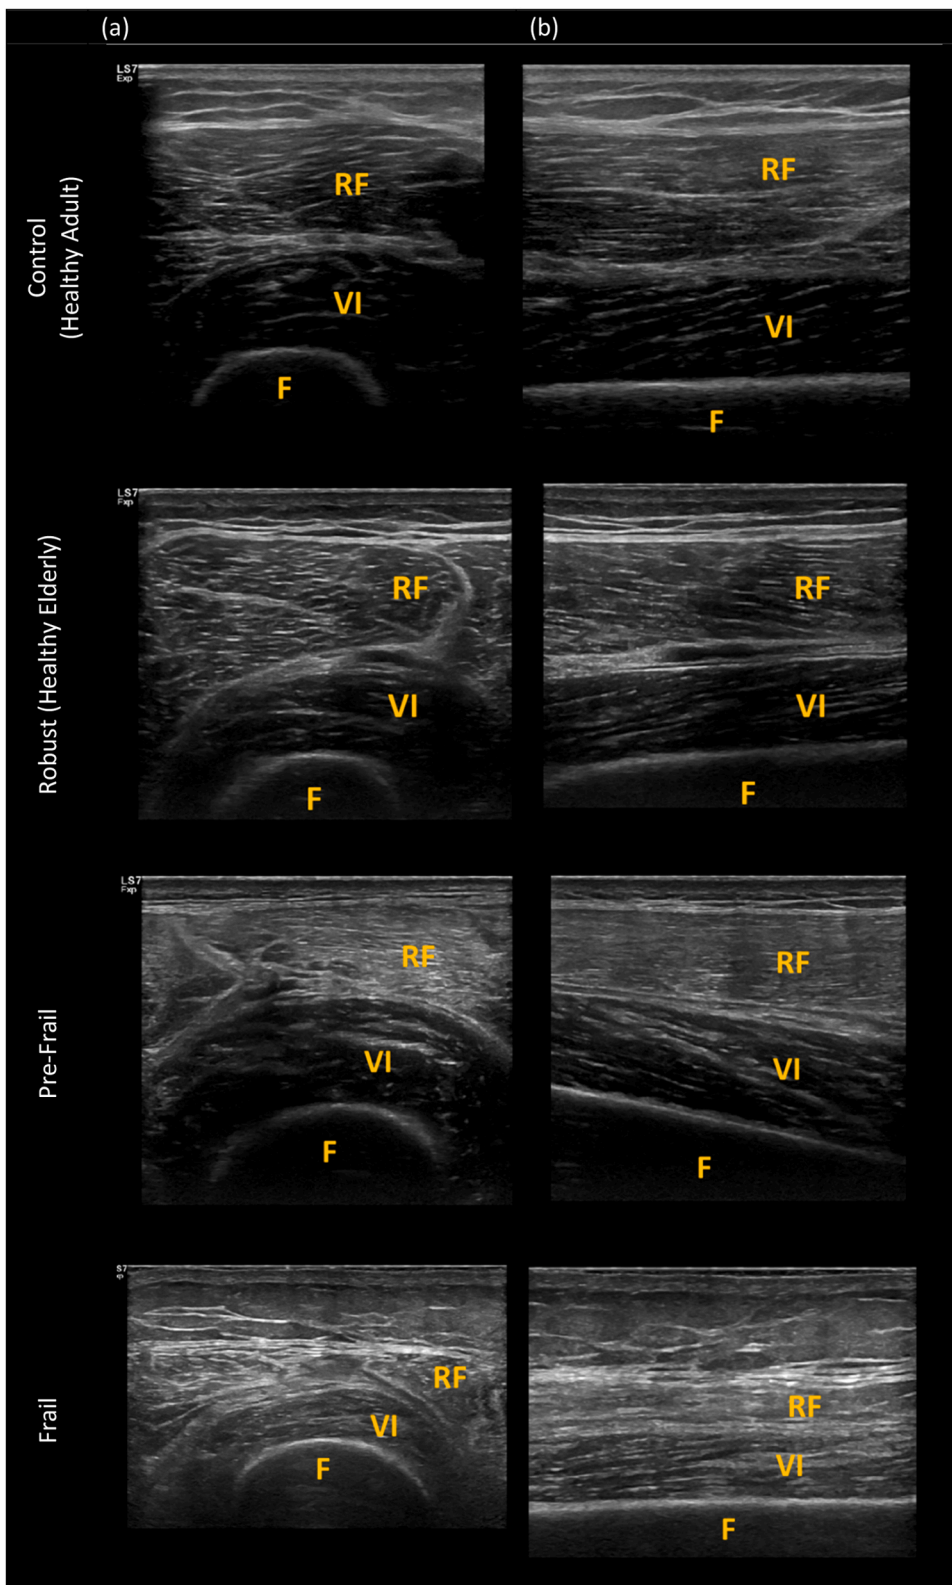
Examples of ultrasound images corresponding to control, robust, pre-frail and frail participants: (a) axial and (b) sagittal images of the anterior mid-thigh. For the frailty condition, a progressive increase of the echo intensity (increased whiteness) in the rectus femoris and vastus intermedius muscles can be observed; as well as a change in muscle structure, changing from a well-defined striated muscle to a less defined, blurry structure. With the advance of frailty, a progressive decrease in muscle thickness can be also observed. Abbreviations: RF: rectus femoris; VI: vastus intermedius; F: femur.
